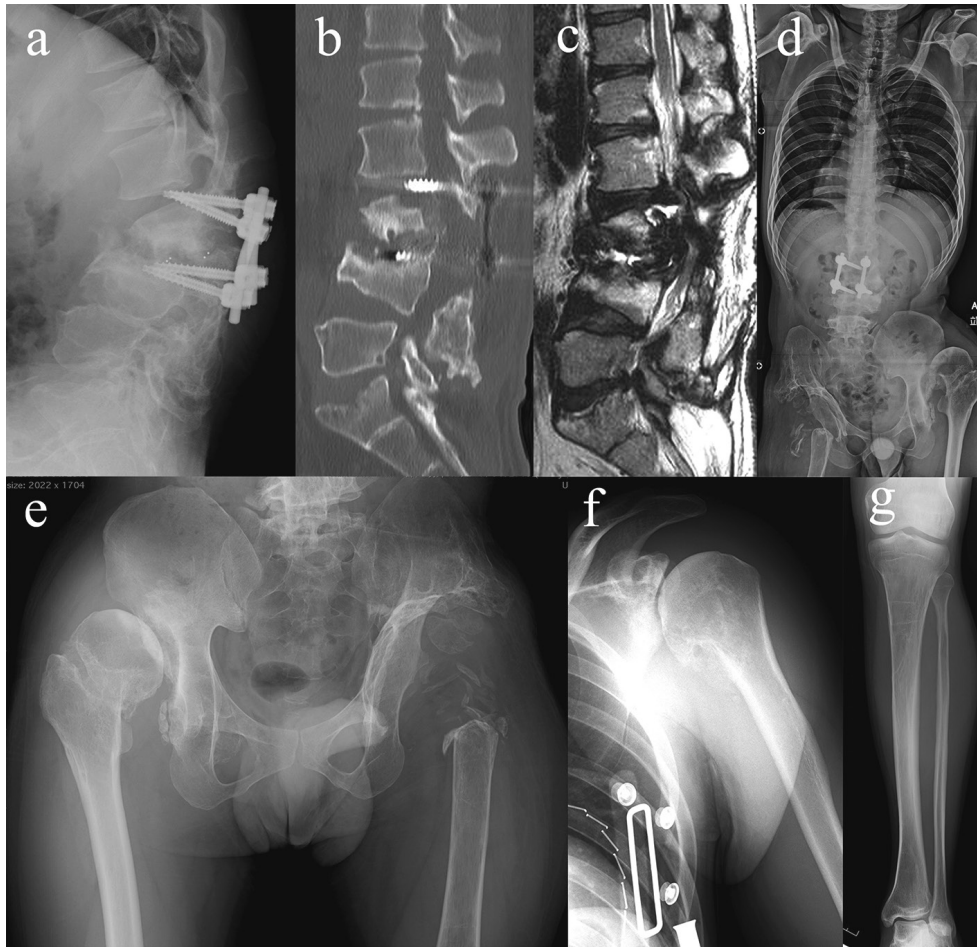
Images at approximately 2 years after L2-L3 posterior lumbar interbody fusion at the age of 30. (a) Lumbar lateral radiogram. Sagittal section of lumbar computed tomography (b) and magnetic resonance imaging (c). Anteroposterior radiograms of the whole spine (d), hips (e), left shoulder (f), and left knee and ankle (g).
